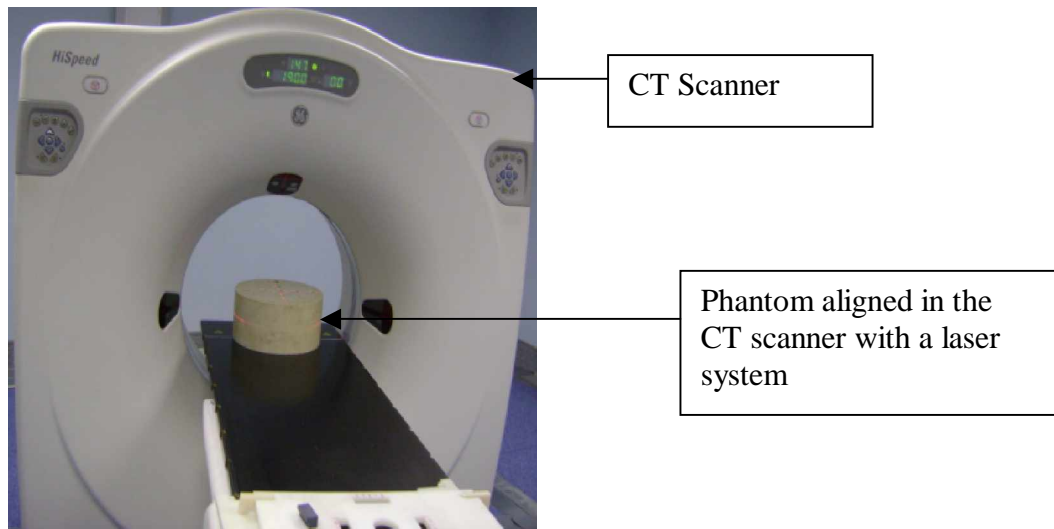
3: Experimental set-up for the measurements of CT numbers of tin, River sand mix, Lincolnshire bolus, dental modelling wax, water and high-density polystyrene.
